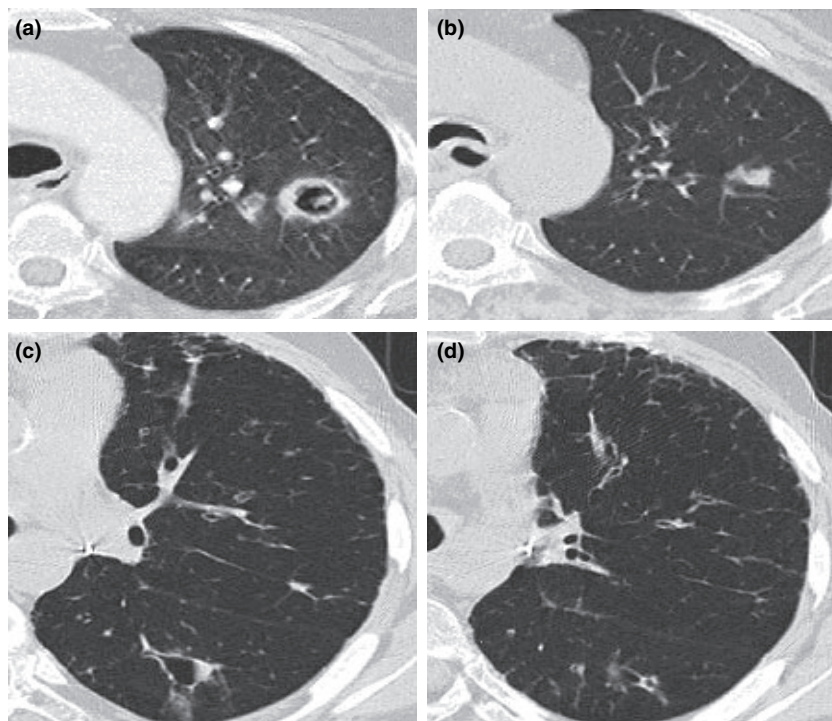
HRCT at diagnosis of invasive pulmonary aspergillosis (IPA; a and c) showing cavitating lesion, and corresponding HRCT images 5 months into oral voriconazole treatment (b and d). (a and b) First case; (c and d) second case.
